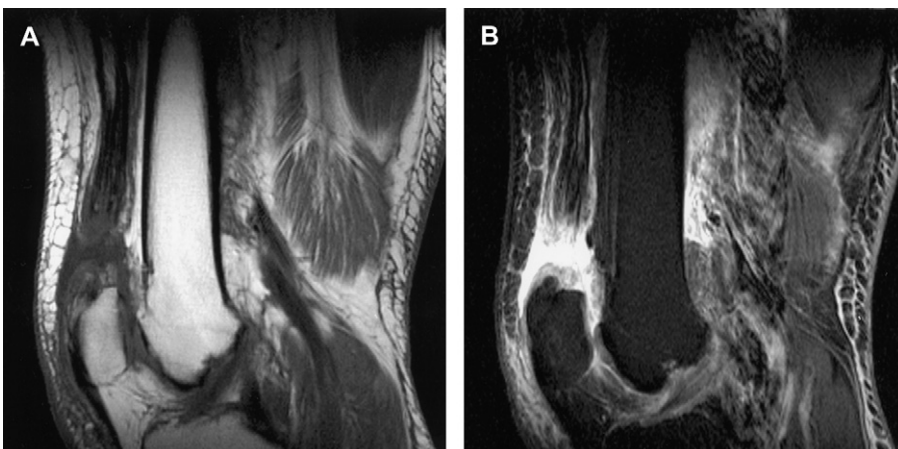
Third-degree quadriceps strain (complete tear). Sagittal T1- (A) and fat-suppressed fast spin-echo T2-weighted (B) images demonstrate thickening and high signal intensity through the quadriceps at the patellar attachment.
